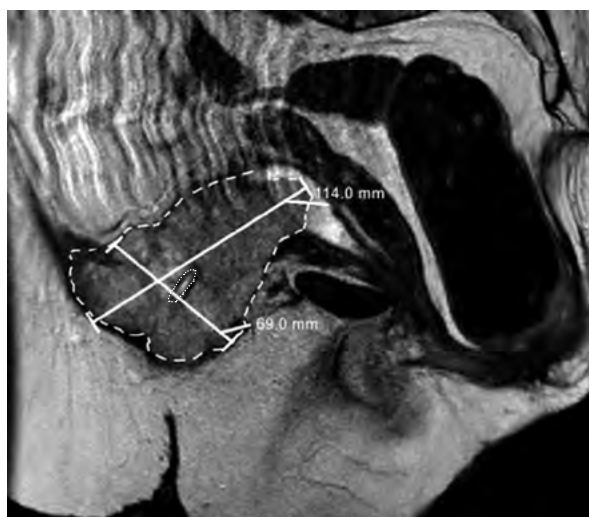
MRI showing a squamous-cell carcinoma (large dashed line) around the suprapubic catheter (small dotted line)
